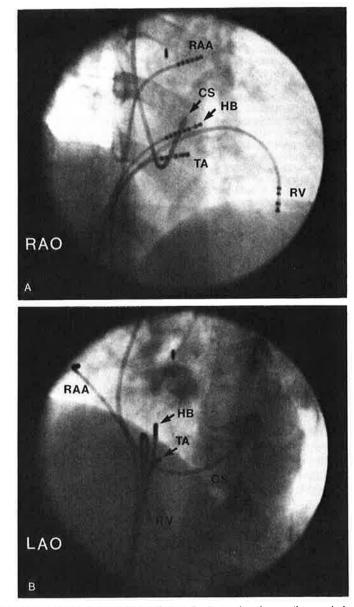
Catheters used to localize an accessory pathway. Radiographs show orthogonal views in the (A) 30-degree right anterior oblique projection and (B) 60-degree left anterior oblique projection. Left free-wall accessory pathways are localized using a catheter in the coronary sinus (CS) to record atrial and ventricular activity close to the mitral anulus as well as accessory pathway activation. Right-sided accessory pathways are localized using a catheter placed against the tricuspid anulus (TA). A catheter is positioned across the anteroseptal tricuspid anulus to record the His bundle activation (HB). In this patient, catheters are also positioned in the right atrial appendage (RAA) and right ventricular apex (RV) for programmed electrical stimulation.
